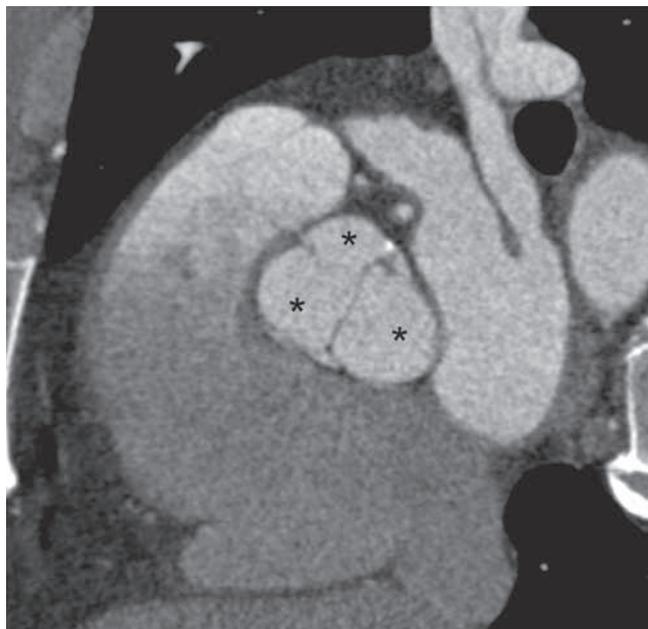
A 65-year-old man with a hypoplastic left coronary cusp on a cross-sectional contrast-enhanced CT image through the aortic valve. The hypoplastic left coronary cusp and left sinus of Valsalva make this valve appear almost bicuspid. Many variations exist in the morphology of the aortic valve. While CT can deliver excellent image quality, the associated radiation exposure and the lack of true functional information makes it not suitable for routine valve evaluation. Consequently, the application of CT for the evaluation of valve morphology must be restricted on a case-by-case basis, and always in conjunction with the findings of echocardiography and magnetic resonance imaging.
